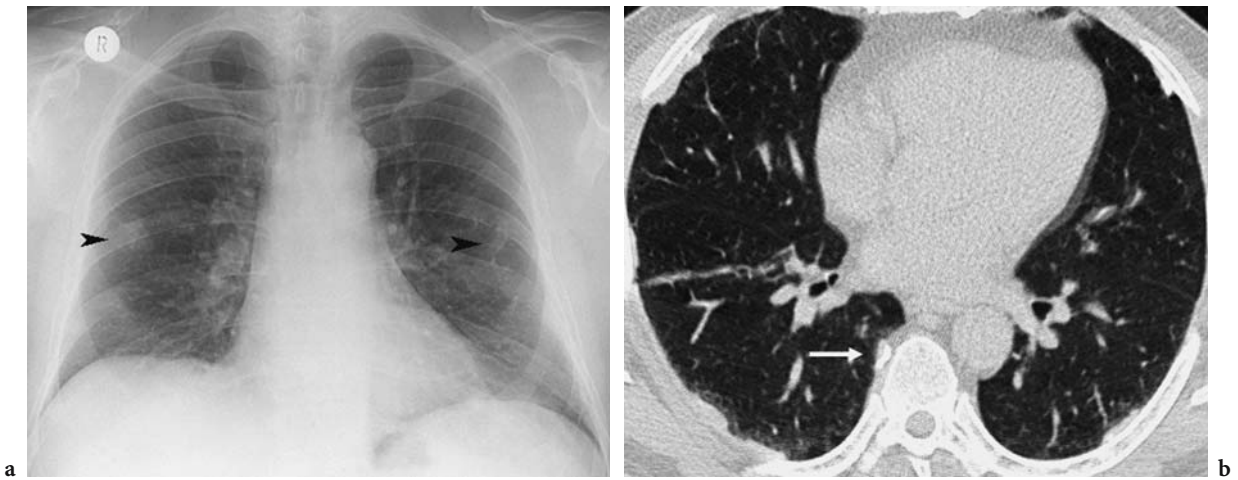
There are abnormal opacities, possibly pleural in origin (*arrowheads*), demonstrated bilaterally on the chest radiograph (a) of a 52-year-old male with asbestos exposure. The thin-section computed tomography (b) shows several well-circumscribed pleural plaques, one located in the right paravertebral region (*arrow*) not visualised on the chest radiograph
